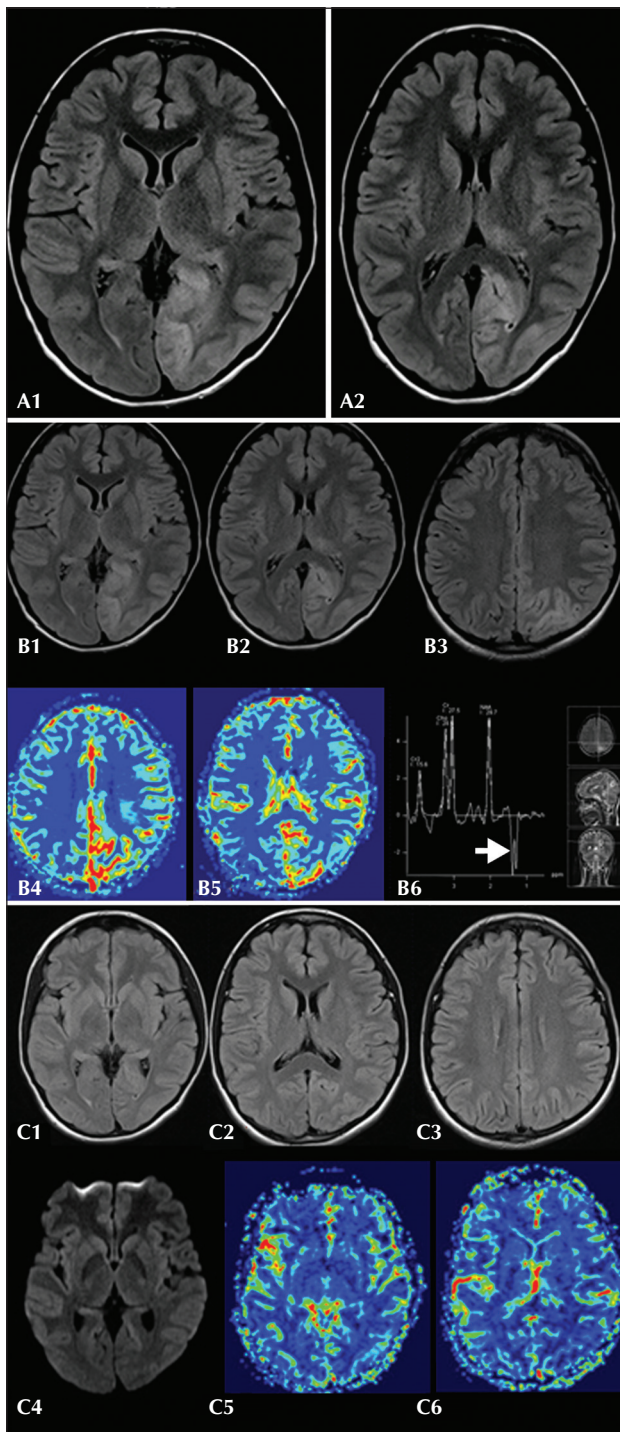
(A) FLAIR axial MRI from November 2013, showing left parieto-occipital gyral swelling (A1 and A2). (B) Images from April 2014 showing the persistence of focal left parieto-occipital gyral oedema (B1-B3) with increased perfusion in the peri-ictal image (B4-B5) and double inverted lactate peak, as indicated by the white arrow (B6). (C) Images from July 2014 demonstrating the disappearance of gyral oedema (C1-C4) and normal perfusion pattern (C5-C6).
